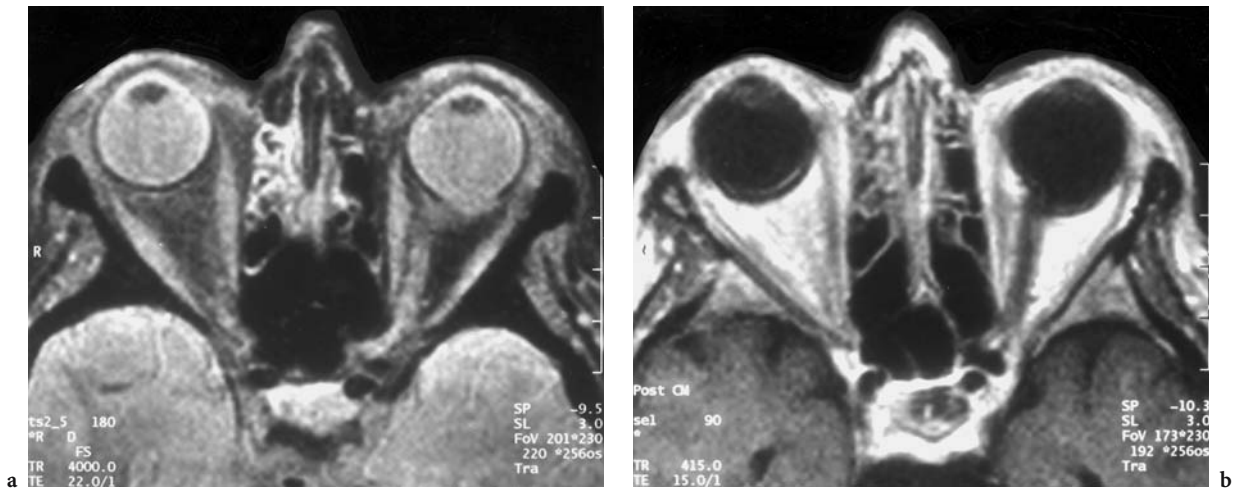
A 71-year-old woman with staphyloma. MRI: a Proton-weighted image with a scleral defect of the posterior circumference of the left globe at the level and lateral of the optic nerve. b Corresponding T1-weighted view demonstrates a marked deformation of the left globe compared with the right globe
